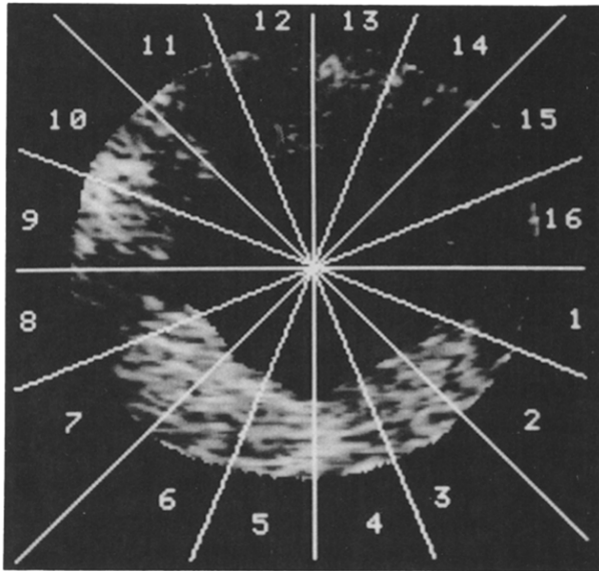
Computerized analysis of the echocardiographic image shown in Figure 2. The ventricular myocardium is automatically divided into 16 sectors of equal angle.
